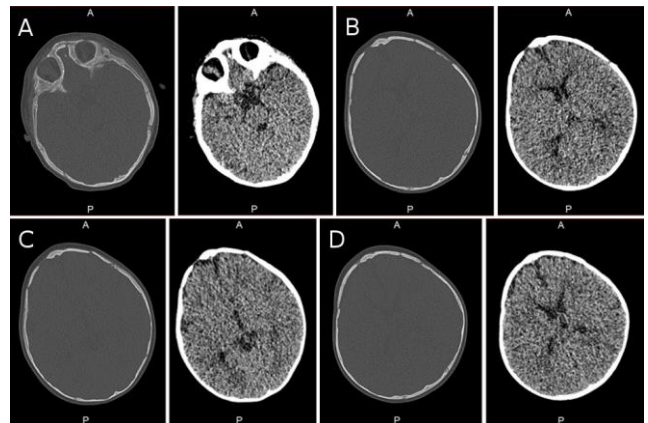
Postoperative head CT scan at 3 months follow up. Note the anterior cranial base decompression
